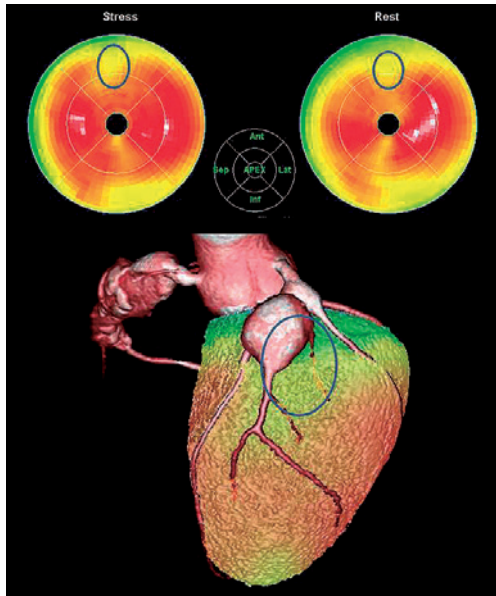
Upper, SPECT Bull's eye; lower, hybrid image. In the upper SPECT images, Tc uptake decreased during both rest and stress in the region enclosed in the blue circle, suggesting infarction. However, a perfusion defect was noted only in the proximal region, as the distal region could not be evaluated on the basis of the general perfusion defect patterns; thus, the diagnosis could not be made with the side-by-side interpretation. In this hybrid image, a region with reduced perfusion was noted directly under the giant aneurysm (blue circle).
